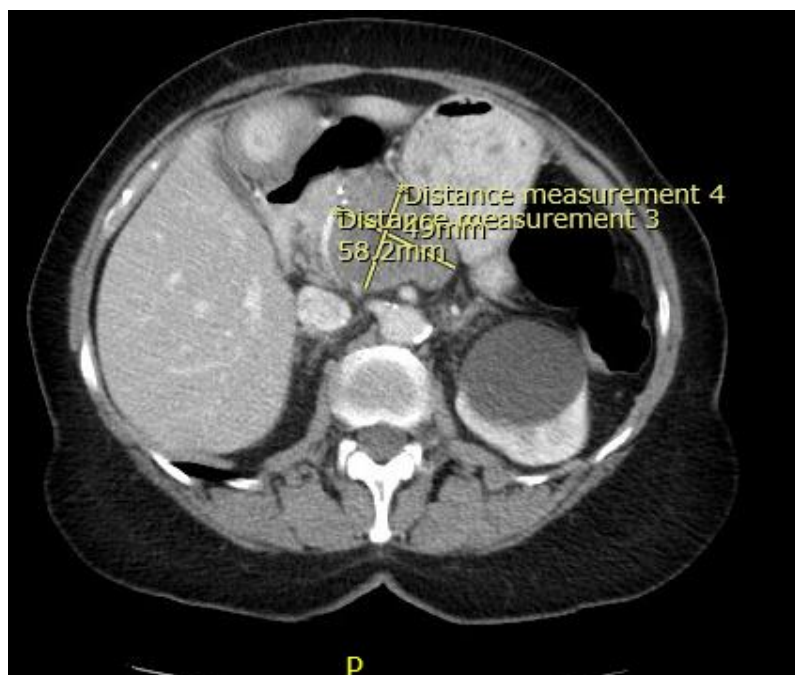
CT Pancreas Recurrence Extending Into the Fundus
